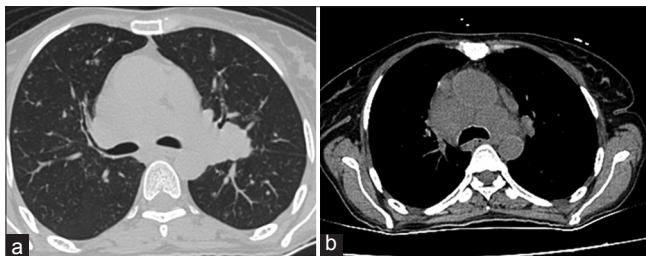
(a) Axial HRCT images reveal multiple discrete nodules in bilateral lung fields. (b) Mediastinal window showing mediastinal lymphadenopathy
